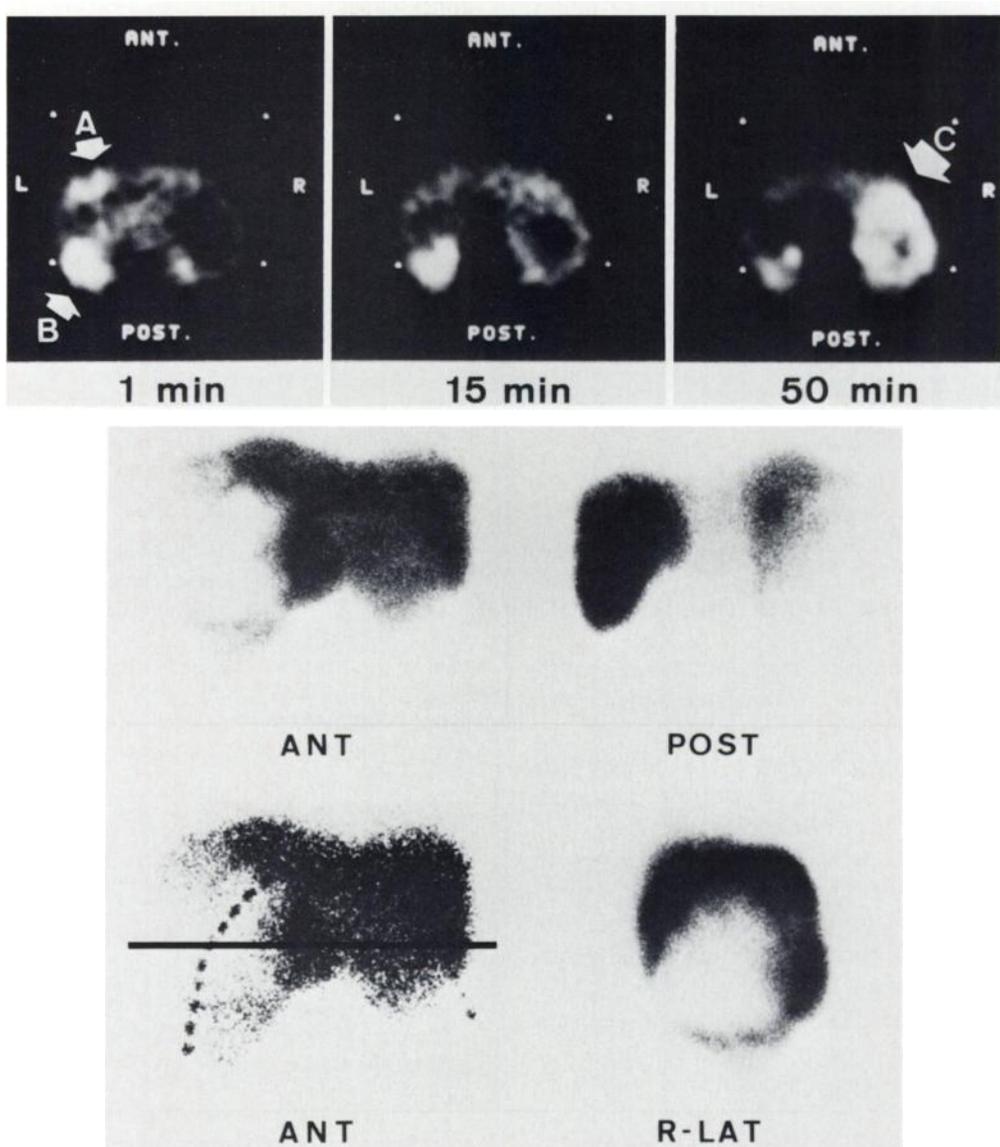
(top) PET images of liver (Case 2) after intravenous injection of F-18-FDG. Images presented use a single linear gray scale to display changes in tracer content with time. Initial high activities in left lobe of liver (A) and spleen (B) decrease gradually, whereas markedly increased uptake in tumor (C) is shown on late image. (bottom) Conventional liver scans of same patient (Case 2). Slice level of PET images is shown by black line.
